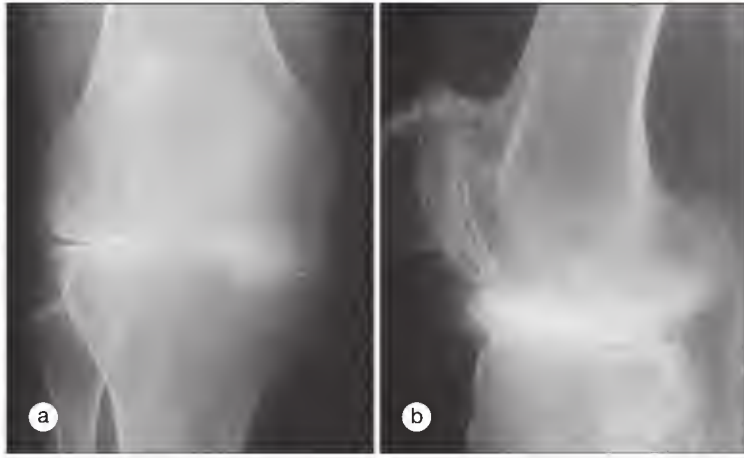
Knee radiograph of patient with coexistent rheumatoid arthritis and calcium pyrophosphate deposition. On the anteroposterior view (a), widespread cartilage loss is evident, but the lateral view (b) shows marked new bone formation atypical of rheumatoid arthritis.
